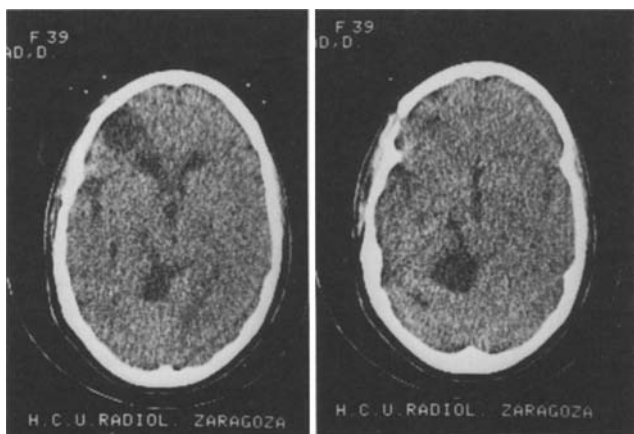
Post-operative CT brain scans show hypodensity of the frontal lesional regions with discrete dilation in the left-frontal horn and an infratentorial cyst which is distorting the quadrigeminal cistern
